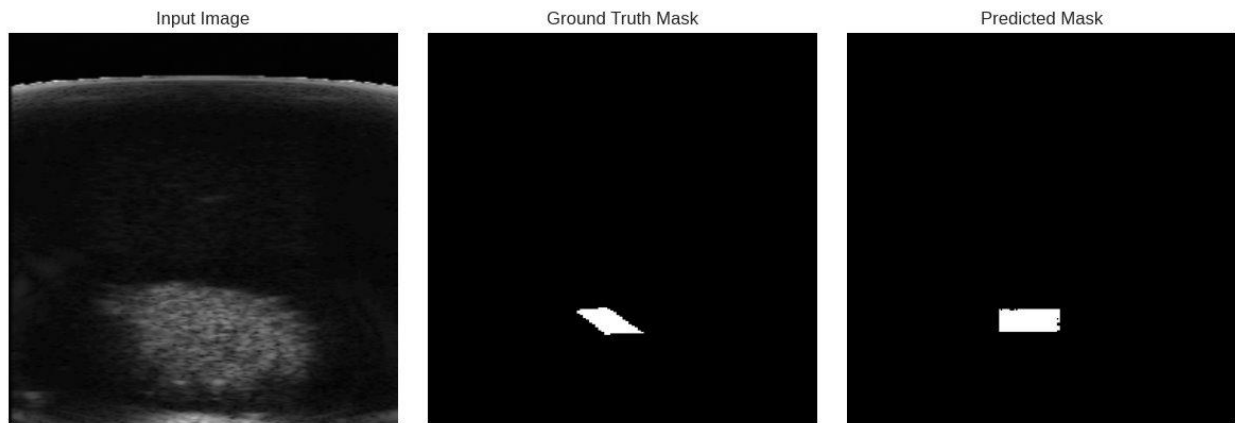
Prostate B-mode ultrasound image (left), reference annotation of stromal area (middle), and SAM2 segmentation (right).
